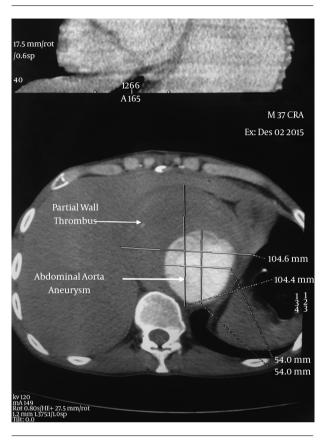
Computed Tomography Angiography Shows a 10-cm Abdominal Aorta Aneurysm With a Partial Wall Thrombus
